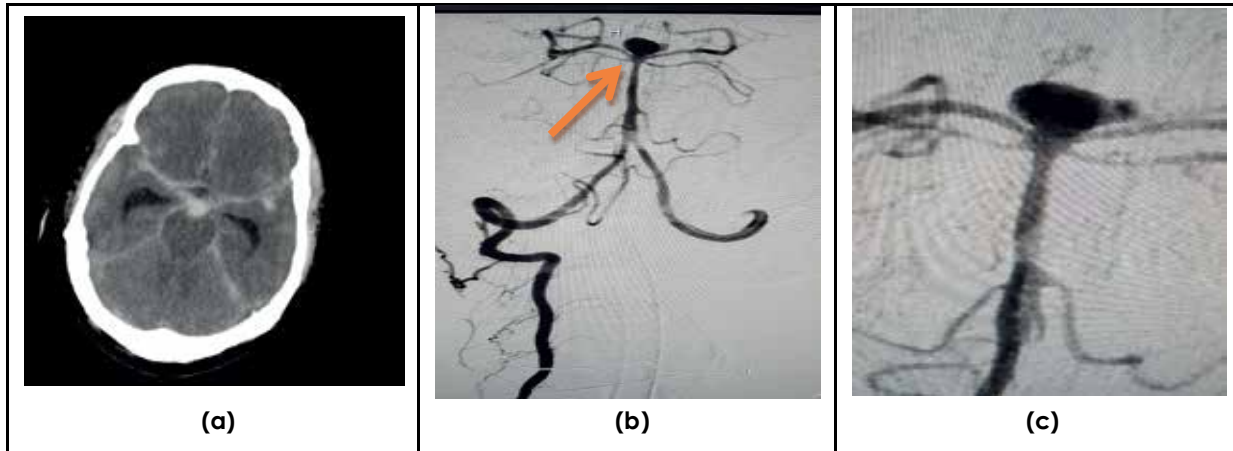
CT brain showing diffuse subarachnoid hemorrhage (SAH); b: Digital subtraction angiography (DSA) reveals a basilar tip aneurysm (arrow); c: A zoom in image of the aneurysm.
